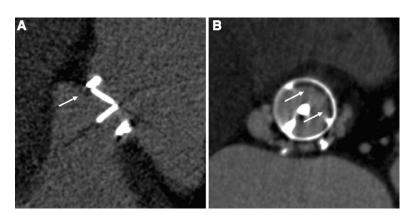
Prosthetic valve pathology detected with computed tomography. A, Obstruction of an ATS mitral valve because of hypodense tissue (arrow) based on thrombus formation. B, Pannus tissue (arrows) underneath a Medtronic Hall monoleaflet valve.
